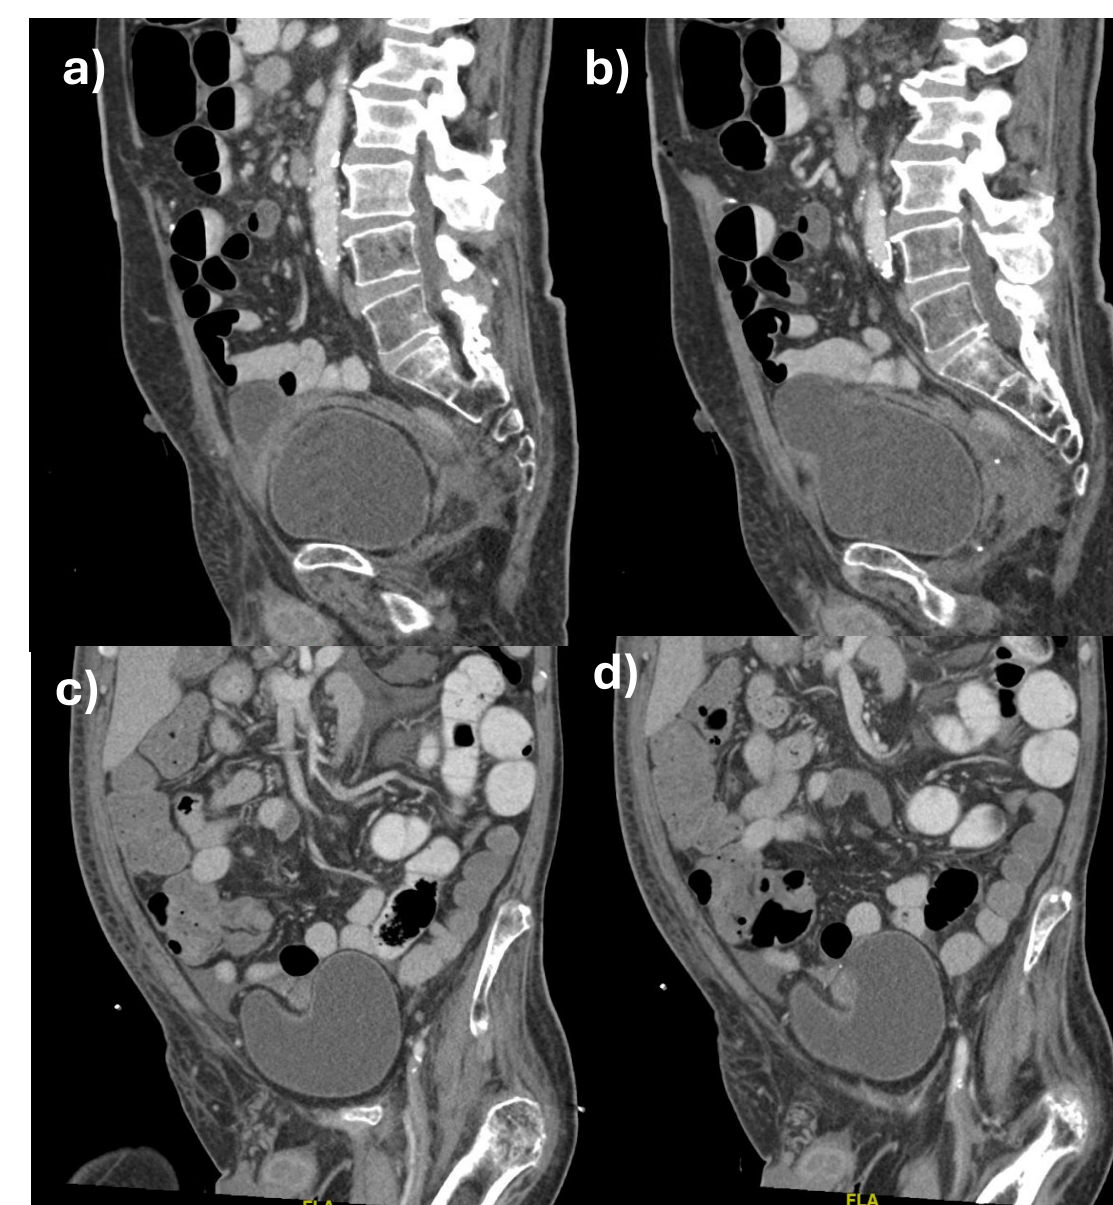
CT images taken POD 13 demonstrating bladder distention and VRAM flap congestion in a-b) sagittal and c-d) coronal views
